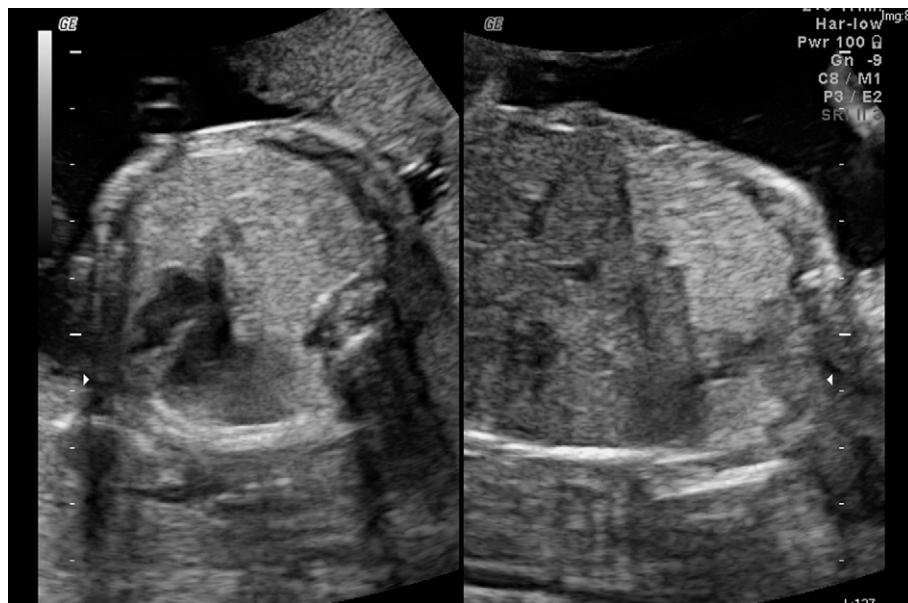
Prenatal 2-D ultrasound of congenital cystic adenomatoid malformation of the lung (CCAML) type III at 21 weeks of gestation.
